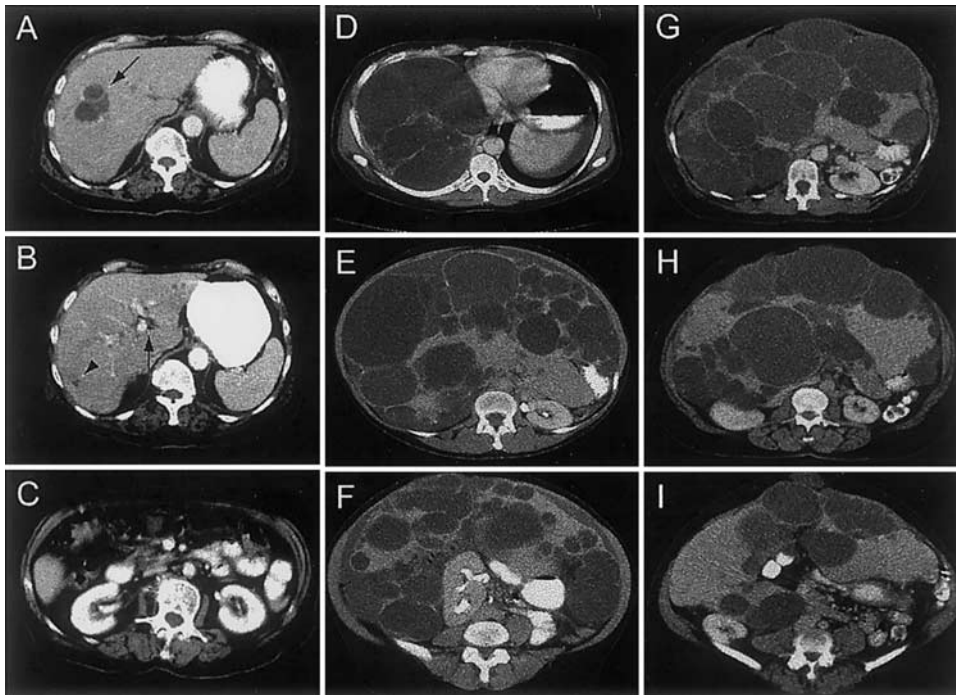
Computed tomographic scans from 3 patients, showing various degrees of severity of the polycystic liver disease. Note the presence of peribiliary (arrows) and peripheral (arrowhead) cysts in the patient with milder polycystic liver disease (A-C). Note the displacement of the kidneys by a massively enlarged liver in the two patients with more severe disease (D-I). The kidneys are normal and contain no cysts.
